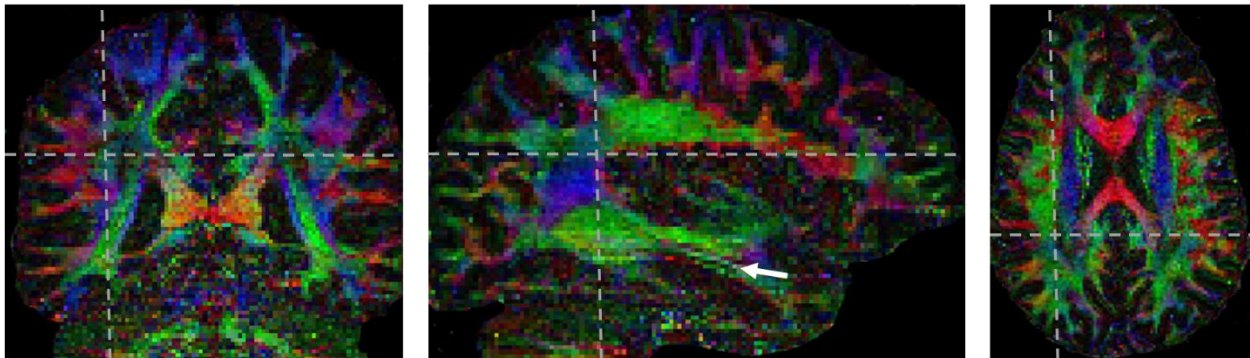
Fractional anisotropy images from a 1.25 mm resolution 30 direction DWI data set. Fine structures, such as parts of the hippocampus (arrow) are more easily delineated at higher resolutions.
